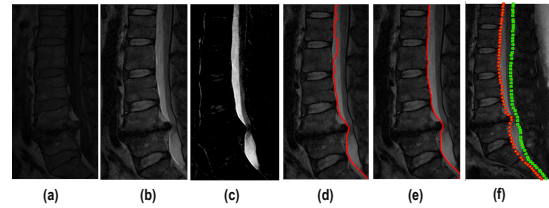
Whole process. (a) A T1-weighted sagittal image, (b) a T2-weighted sagittal image, (c) difference of intensity between T1- and T2-weighted images, (d) the boundary output generated by the intensity-based method, (e) the boundary output generated by the gradient-based method, and (f) the manually-marked reference boundaries.
